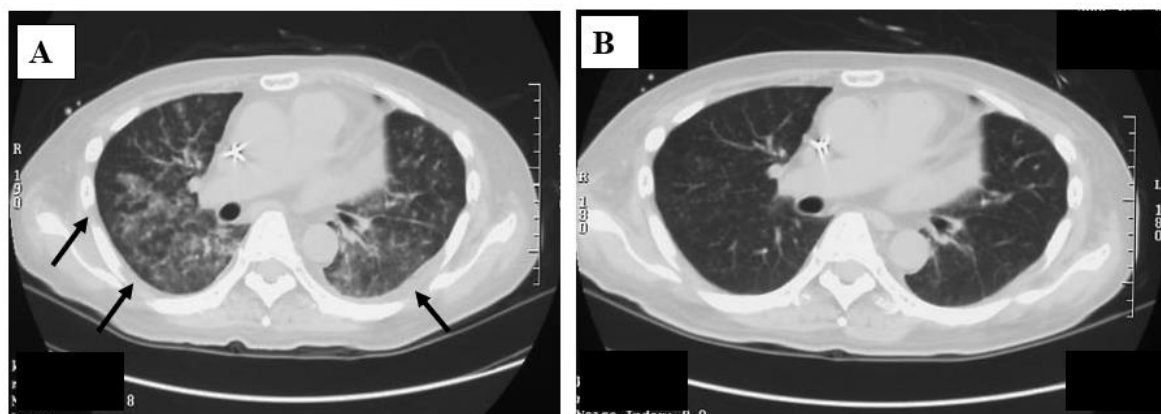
Chest computed tomography findings of a 47-year-old man with cytomegalovirus pneumonia. He was also co-infected with HIV and had been receiving treatment, but bilateral ground-glass shadows are found on admission (A, arrows). Ganciclovir 300 mg/day plus methylprednisolone (mPSL) [Please spell out all abbreviations on first use. Please confirm.] 1 g (x3 days) were started, and he shows improvement 2 weeks later (B).
